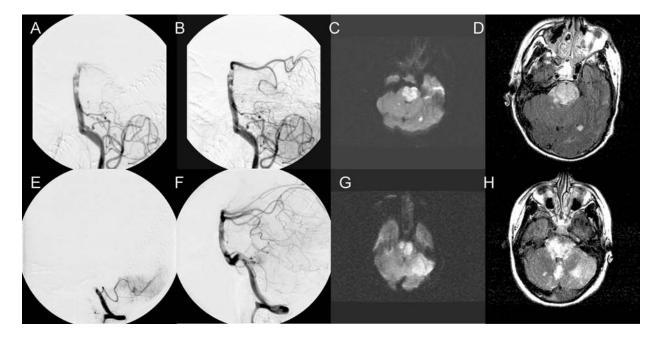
Cerebral angiography (A, B, E, F) diffusion weighted MRI (C, G), and axial FLAIR sequence MRI images (D, H) of patient 1 (A, B, C, D) and patient 2 (E, F, G, H) showing basilar artery thrombosis, recanalization, and extensive pontine infarctions.
